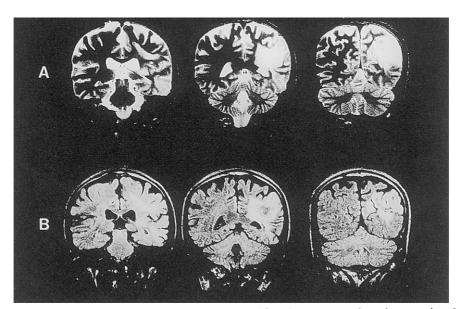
Coronal MR images of the brain on March 4, 1996, showing parietal gray matter involvement. A: T2-weighted images (TR: 4500 milliseconds, TE: 100 milliseconds), B: FLAIR images (TR: 6500 milliseconds, TI: 2000 milliseconds, TE: 100 milliseconds).
